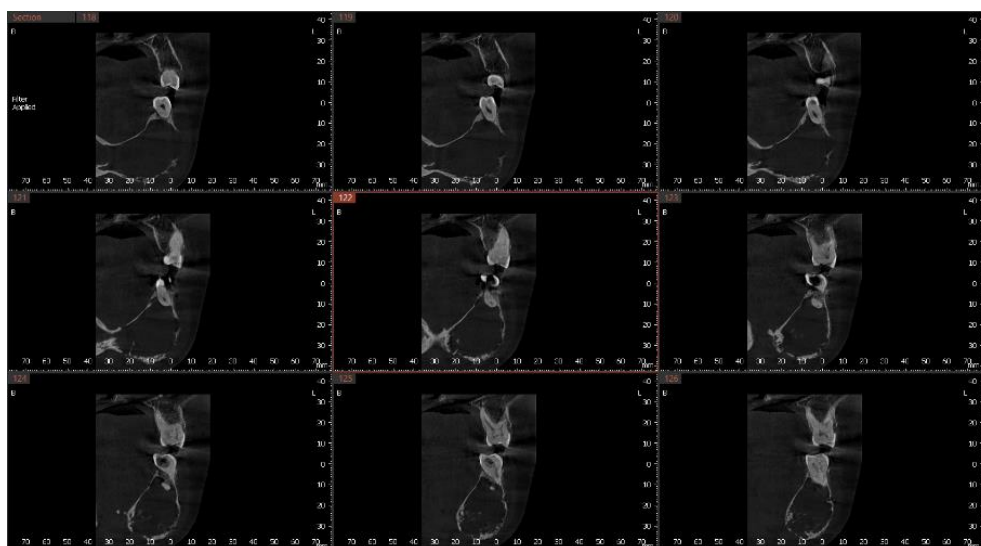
CBCT cross sections at 1 mm intervals showing cortical thinning with perforation and erosion of buccal and lingual cortex
